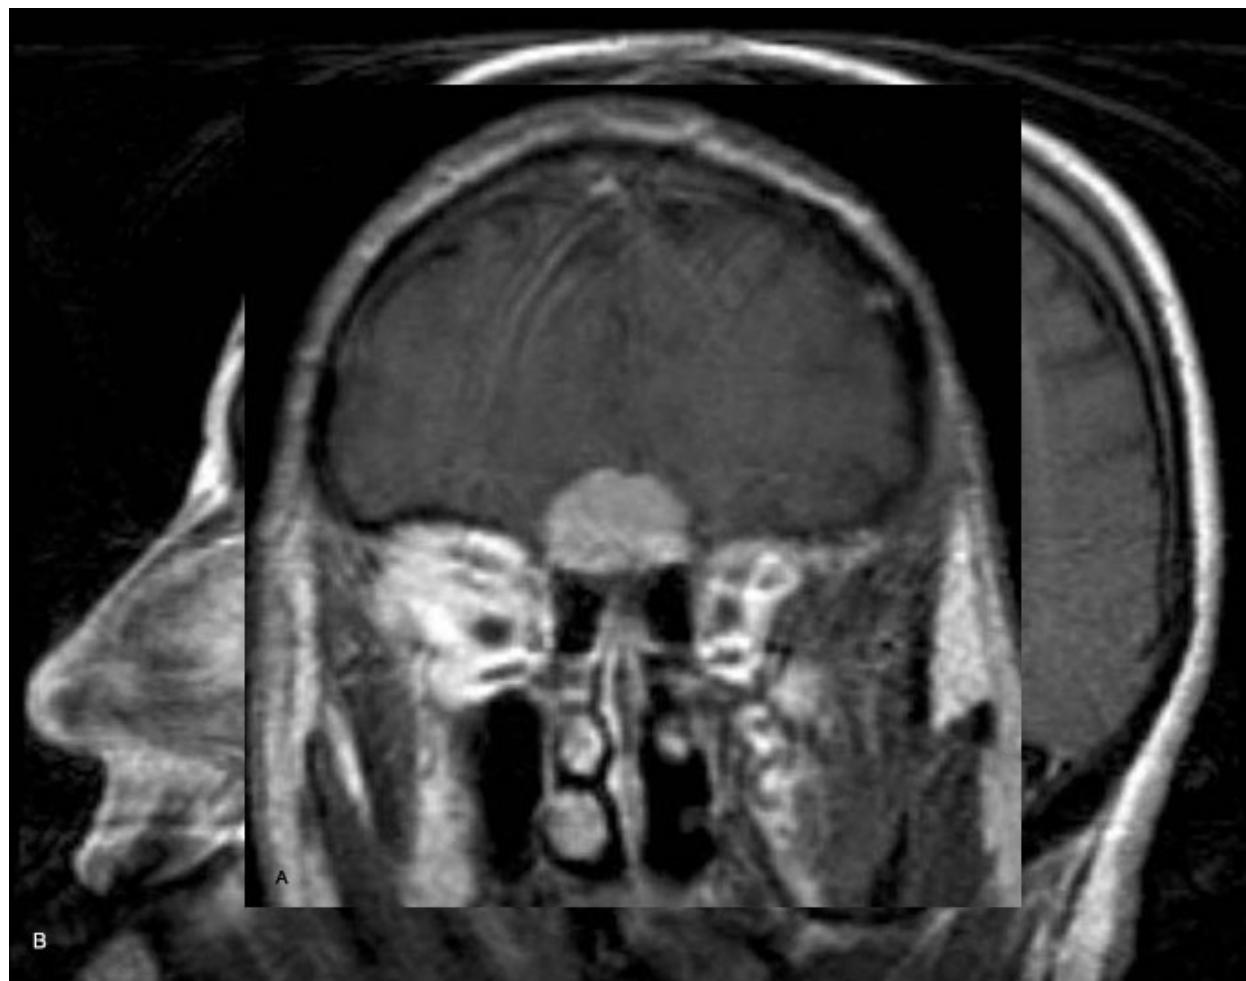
Coronal (A) and Sagittal (B) T1-weighted post contrast images demonstrating a typical olfactory groove meningioma. This patient presented with a generalized tonic clonic seizure.
